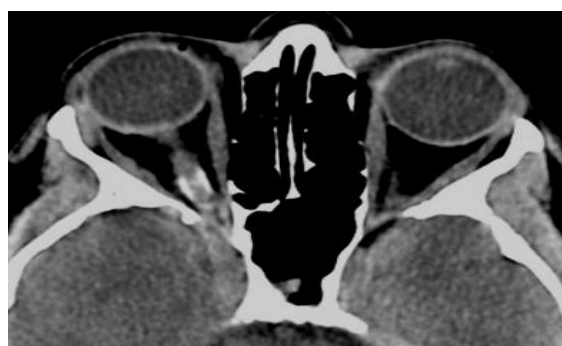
Plain CT show calcification along the right optic nerve - ONSMeningioma
